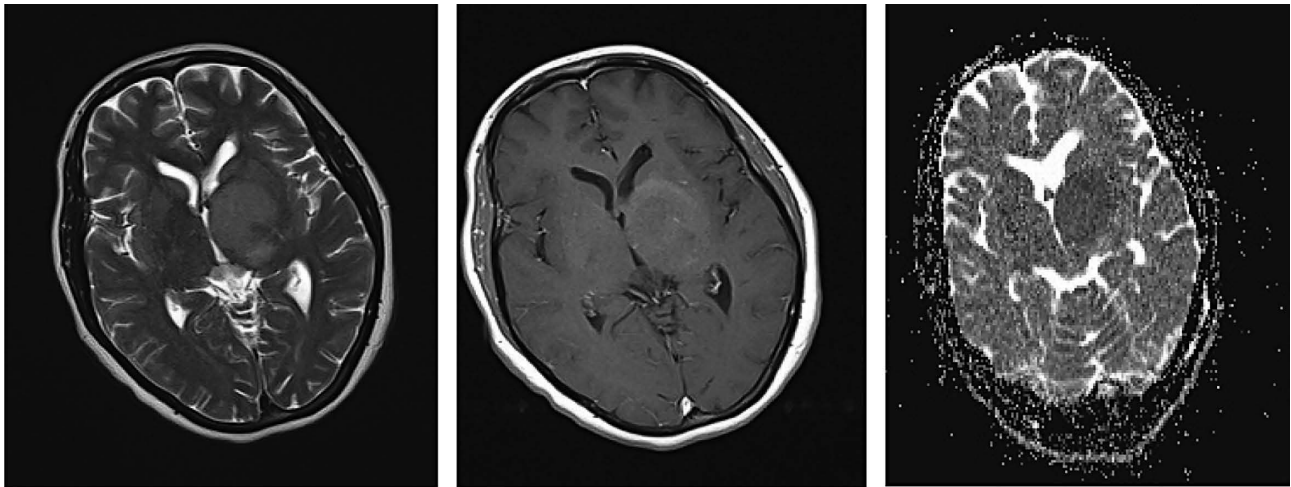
Anaplastic astrocytoma in 34-year-old woman. Transverse (a) preoperative T2-weighted MR image (b) contrast-enhanced T1-weighted MR image and (c) ADC map show well circumscribed shaped enhancing tumor (arrows in a) with minimal edema in left basal ganglia. Minimum ADC value was $0.592 \times 10^{-3} \text{ mm}^2 \cdot \text{sec}^{-1}$.
